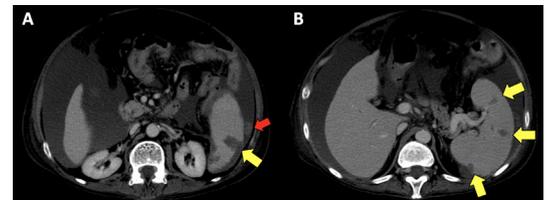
Contrast-enhanced CT scan of the abdomen performed in the portovenous phase (A,B), demonstrating the diffuse extent of splenic rupture, with involvement of multiple sites (yellow arrows). Haemoperitoneum (red arrows) is once again seen at the perisplenic region.
